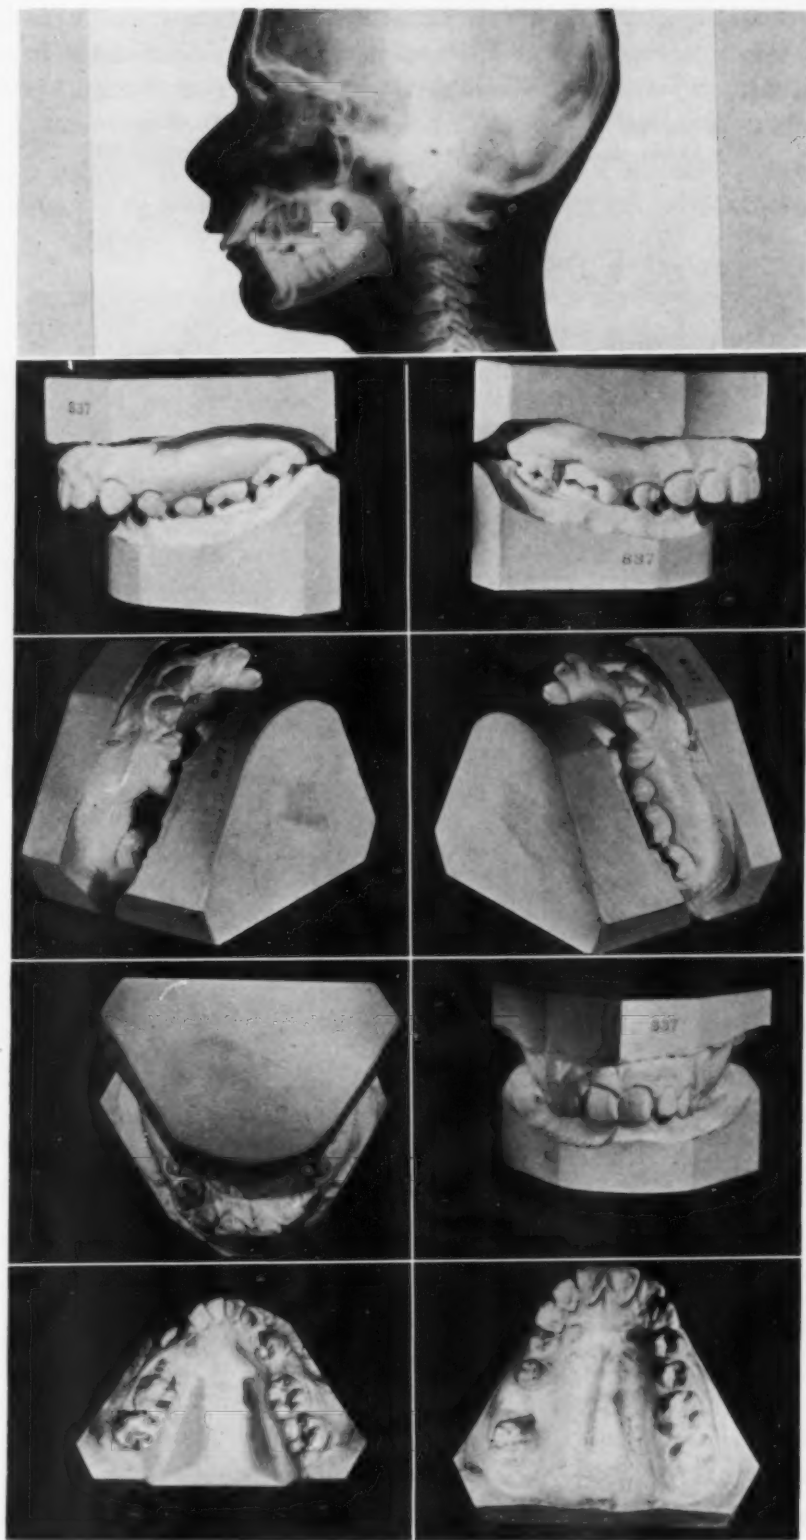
Headplate x-ray and models of a Type A, subdivision II case. Note the close proximity of the posterior border of the ramus in relation to the vertebral column.
